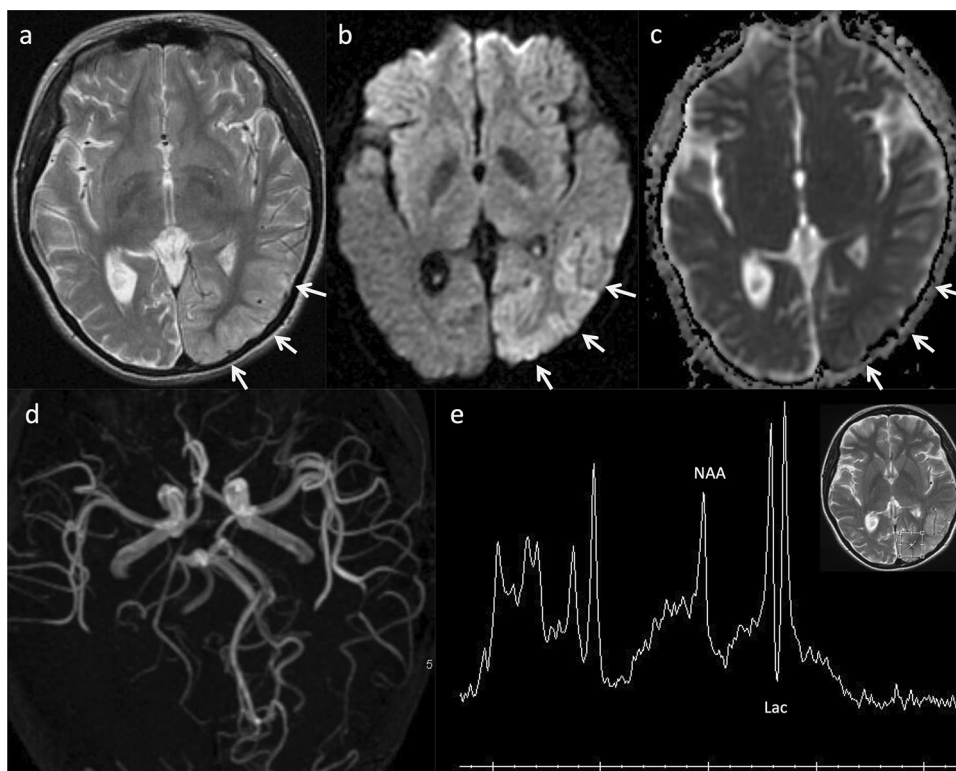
MELAS with point mutations of m.3243A>G in the mitochondrial DNA tRNA-leucine (MT-TL1) in a 10-year-old, female patient with transient visual impairment. Axial T2-weighted imaging (a) demonstrated mild swelling and hyperintensity in the left temporal and posterior cortices (arrows). Axial DWI (b) demonstrated hyperintensity in the left temporal and posterior regions, and an ADC map (c) demonstrated corresponding, increased diffusion (arrows).
